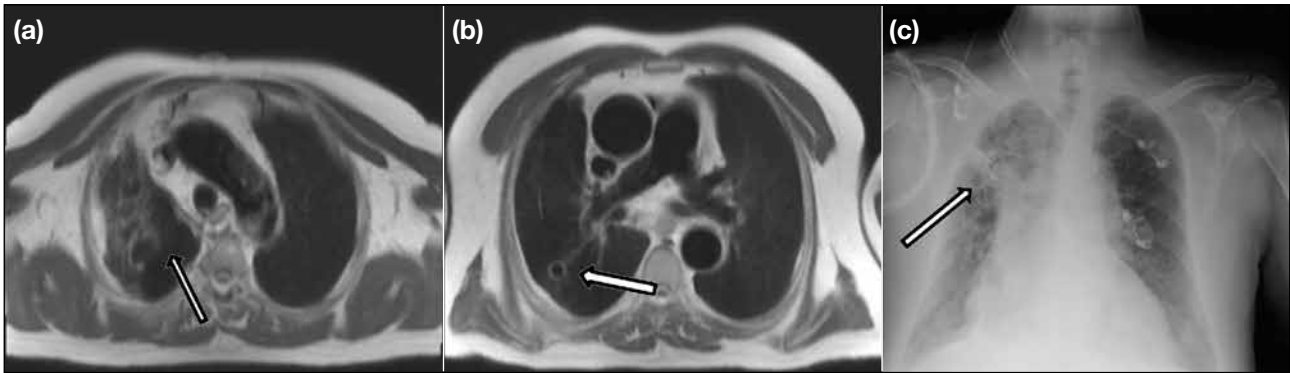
A 62-year-old male presented with atrial fibrillation and dilated cardiomyopathy. He was found to have viable myocardium in cardiovascular magnetic resonance imaging and normal coronaries in coronary angiography. (a and b) Axial black-blood magnetic resonance imaging showing fibrosis and cavitation in the right upper lobe (arrows). (c) Radiography of the chest confirms the diagnosis, with the arrow indicating the cavitory changes in (a) and (b). The patient was diagnosed with fibrocavitary tuberculosis by laboratory tests.
